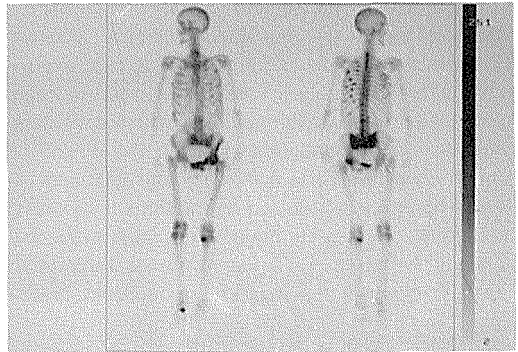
Increased uptake in the ribs, sacrum, sacroiliac joints, head of the left femur, os pubis, knees, small joints of the right foot and along both femurs – fractures? The scintigram is not typical for osseous metastases.
